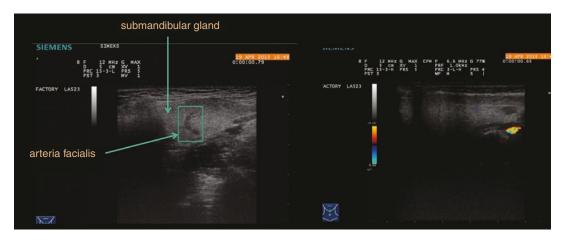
The facial artery in relation to the submandibular salivarty gland. B-mode (A) and Color Doppler examination (B)
